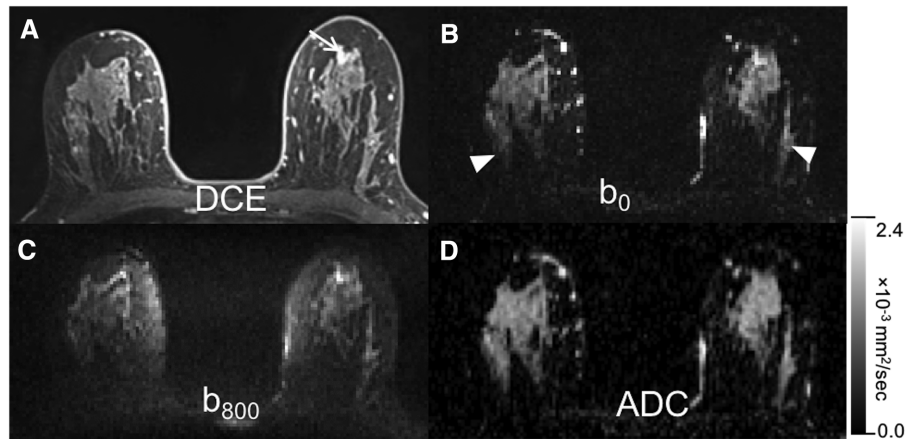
Example of poor fat suppression in a 53-year-old woman undergoing 1.5T MRI for high-risk screening. Dynamic contrast-enhanced (DCE) MRI (A) demonstrates a 9-mm area of linear non-mass enhancement in the left breast (arrow), assessed as BI-RADS category 3. On diffusion-weighted imaging (B and C), unsuppressed fat results in a chemical shift artifact of fat signal displaced (by a few centimeters in the right–left phase-encode direction) and overlaid on the image (arrowheads), thereby decreasing lesion visibility and artificially reducing the resulting lesion apparent diffusion coefficient (ADC) value (D). In this example, ADC values and lesion visibility on the ADC map are impacted due to poor fat suppression resulting in a more pronounced chemical shift artifact.
